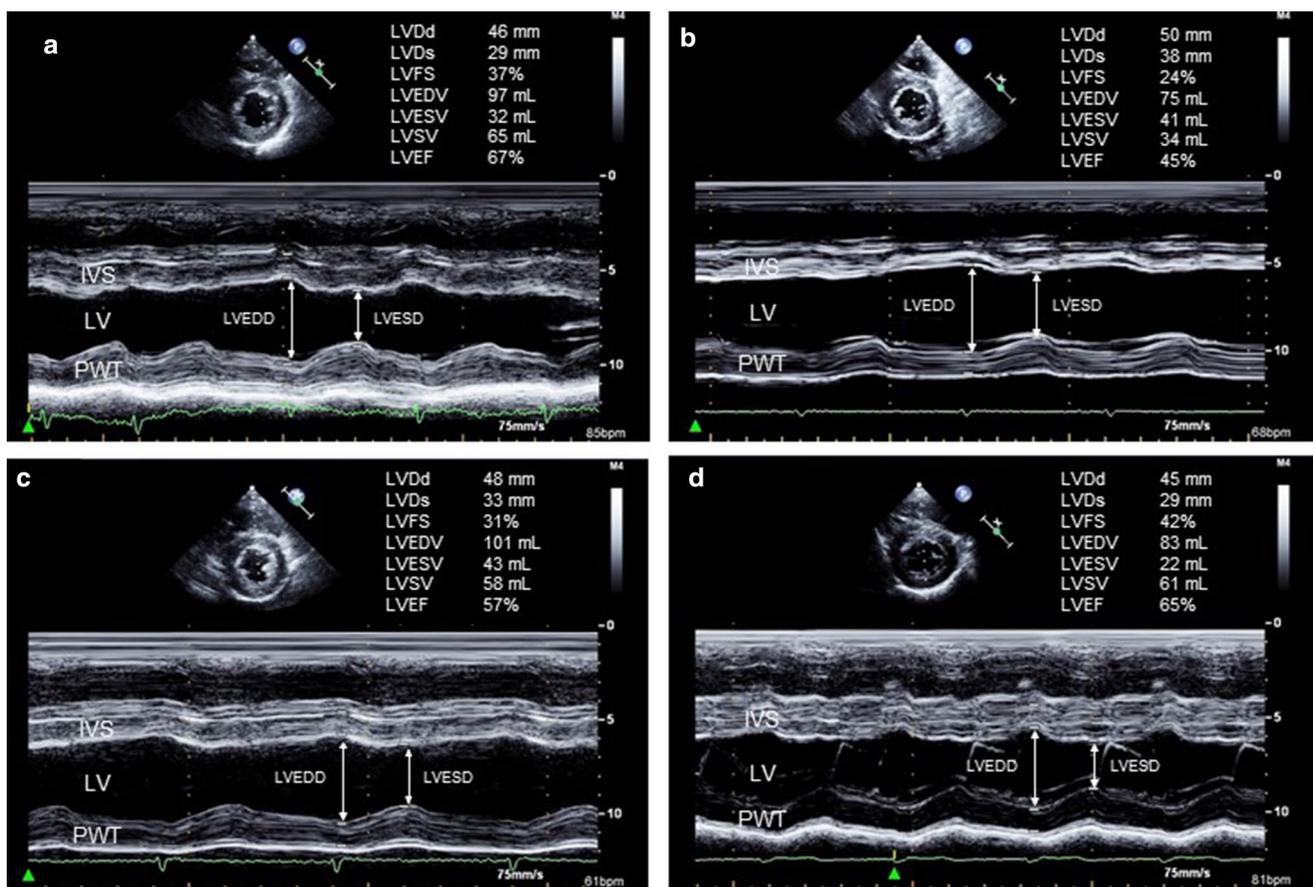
M-mode echocardiography of the presented case. a 2 weeks before administration, b 4 weeks after administration, c 2 weeks after cessation, and d 5 months after cessation of abiraterone. LVEF was decreased at 4 weeks after administration of abiraterone (b), which improved 2 weeks after cessation of abiraterone (c). Further improvement of LVEF was noted 5 months after cessation of abiraterone (d).
